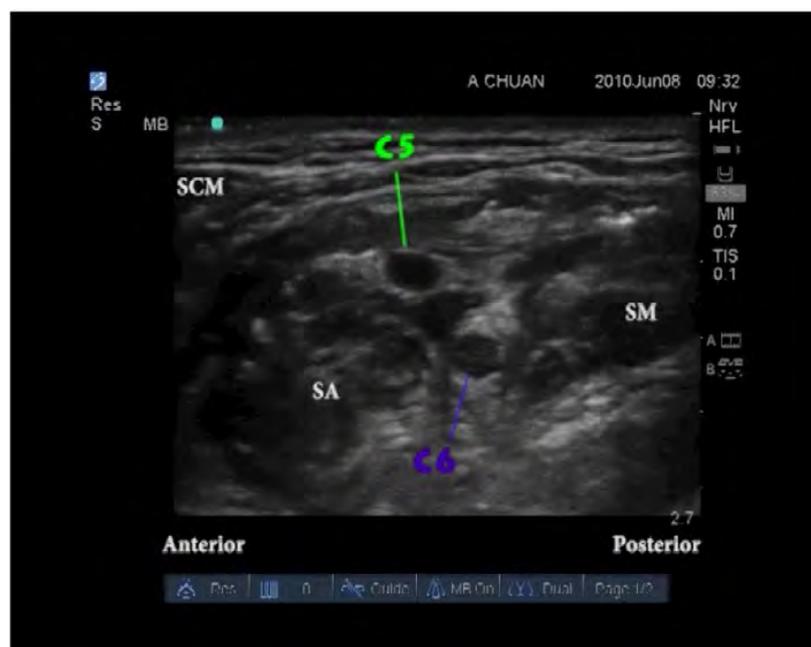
Still frame from another video loop of a variant C5 root distinct and separated from the C6 root. This C5 root will also move anteriorly and superficial to the scalenus anterior muscle when it is traced back proximally to the intervertebral foramen. Note this still frame was taken post-interscalene block; attention must be paid to ensure optimal local anaesthesia spread during ultrasound guided block given the variant anatomy.
